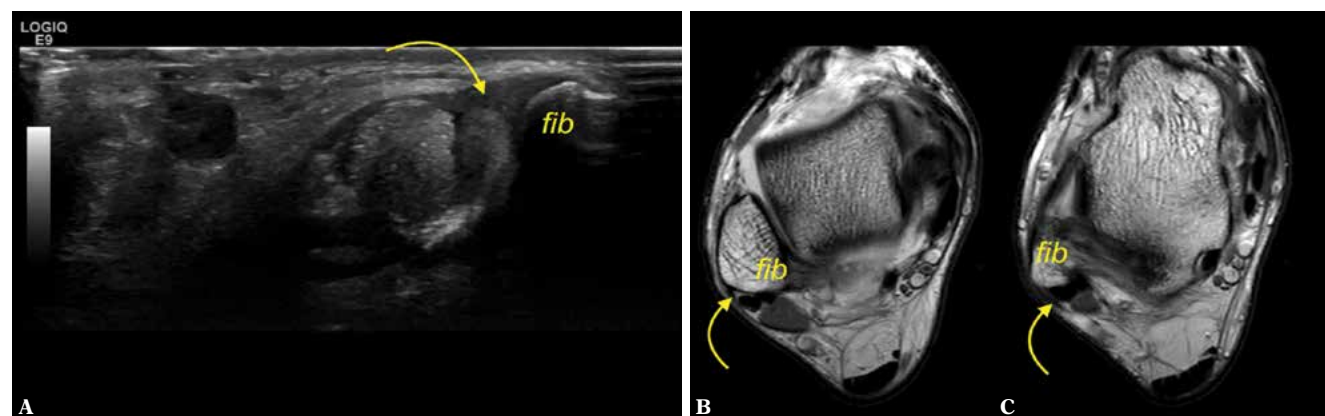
A 19-year-old patient with a clinical suspicion of rheumatoid arthritis. A. ultrasound, transverse section. B, C. proton density-weighted transverse sections. *Fib* – fibula. *SPR* – curved arrow. No connection with IER is present
